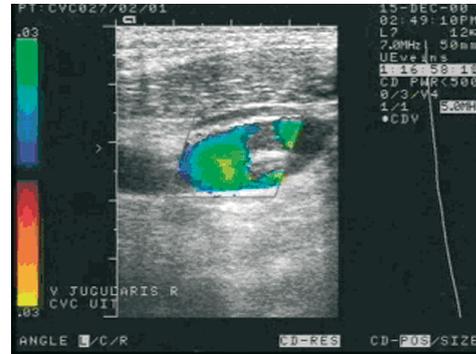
Nearly occlusive mural thrombosis visualised by a flow defect, detected by colour Doppler flow imaging, just after catheter removal
